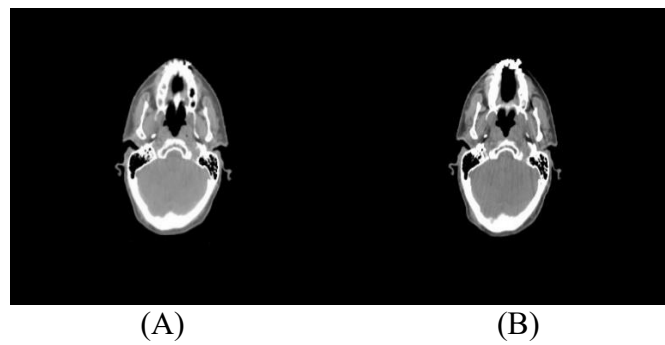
3 Representative axial neck CT images from one of the selected patients: (A) prior to radiotherapy, (B) following radiotherapy.
